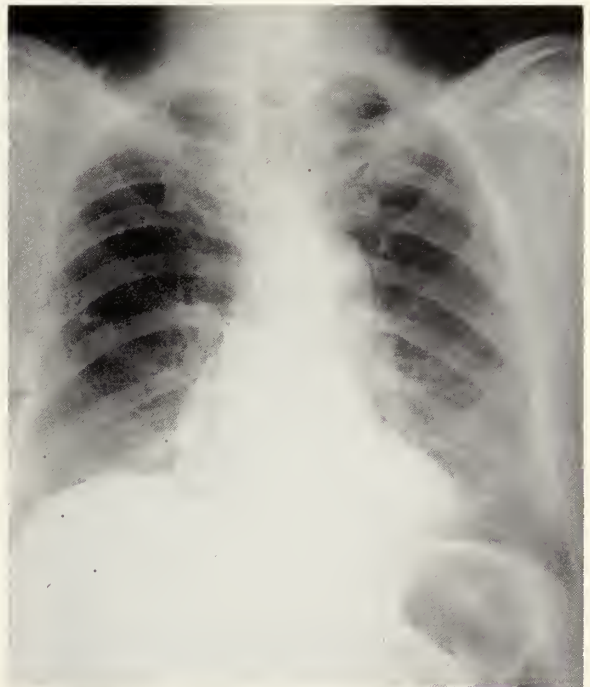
X-ray of chest taken on January 25, 1962.
